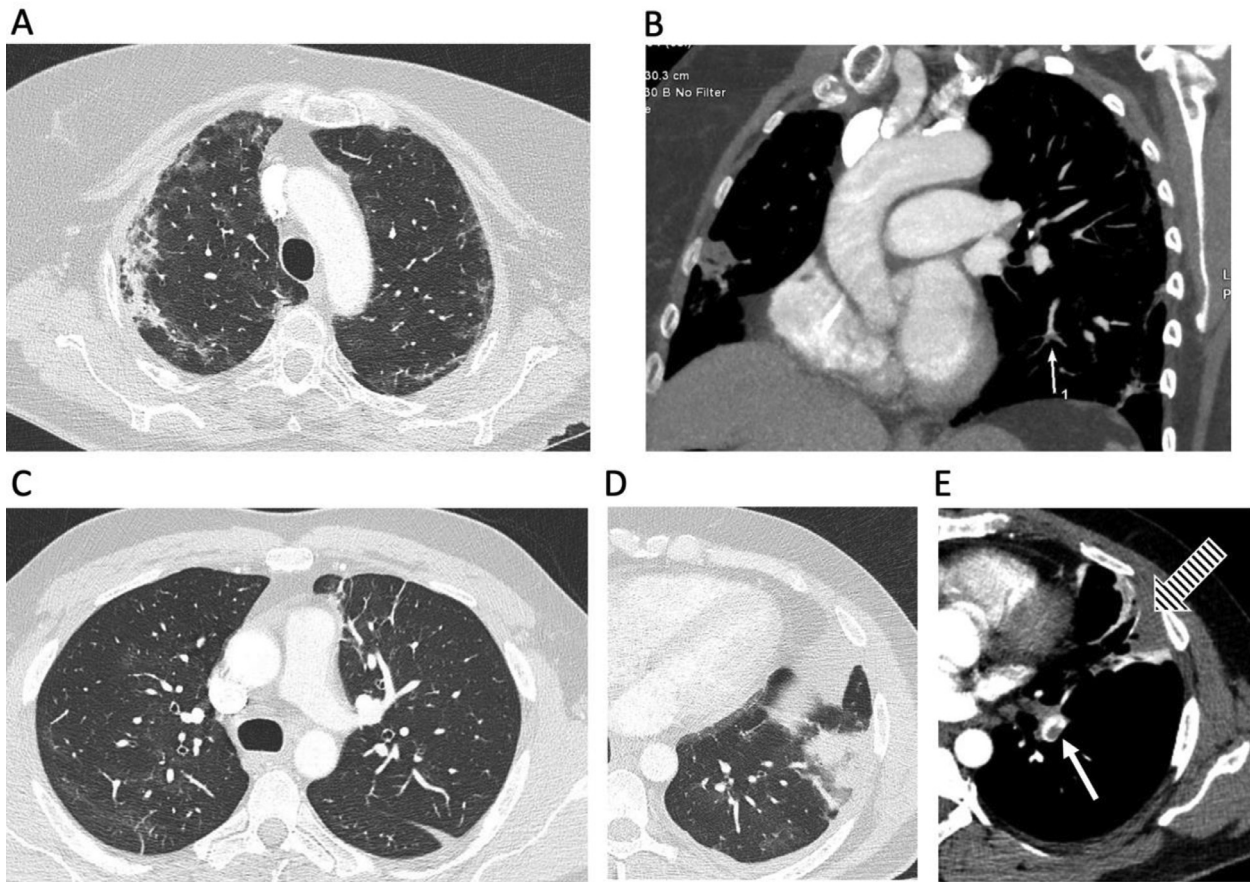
Computed tomography (CT) pulmonary angiography: A and B: a 66-year old female patient hospitalized for COVID-19 pneumonia; axial lung tissue setting (A) and soft tissue setting coronal (B) CT image reconstructions showing characteristic COVID-19 pulmonary lesions with ground-glass opacities and consolidations involving both the lung parenchyma in predominantly peripheral distribution (A) and a subsegmental contrast filling defect (white arrow, B). C, D and E: axial CT image reconstructions of a 38-year old male patient who had fever, cough, dyspnea, and left-side chest pain and was admitted with COVID-19 pneumonia; upper lung levels showing patchy ground-glass opacities in the left lung (C), and left lower lung with a triangular subpleural consolidation (D) corresponding to a pulmonary infarction (red arrow) related to the presence of pulmonary thrombus in the left lower lobe, visible in a soft tissue setting (white arrow, E).
